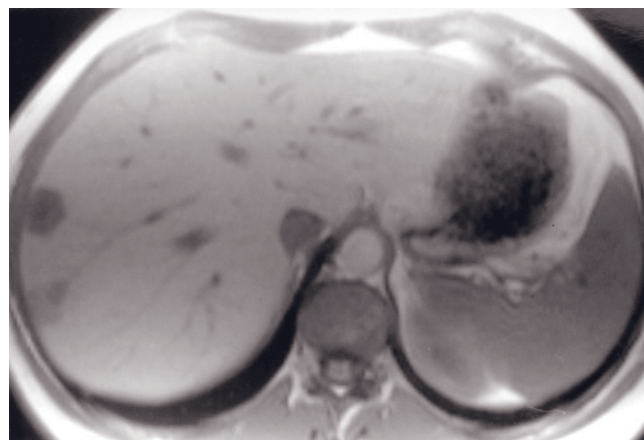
Liver metastases in fatty liver. SGE (a), out-of-phase SGE (b), and immediate postgadolinium SGE (c) images. Multiple low-signal-intensity metastases are present in the liver on the in-phase T1-weighted image (arrow, a). On the out-of-phase T1-weighted image (b), the liver diminishes in signal intensity, rendering the metastases mildly high in signal intensity relative to liver. The immediate postcontrast image (c) shows that the lesions enhance in a peripheral ring fashion, consistent with metastases.
